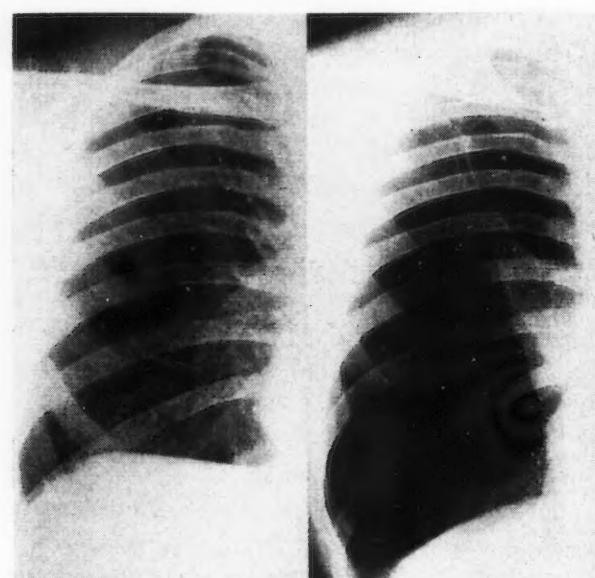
Preoperative (right) and postoperative (left) radiographs of case of multiple emphysematous bullæ of the right upper lobe treated by thoracotomy and excision of the bullæ. Thoracoscopy showed the bullæ and proved that what appeared to be adhesions on the radiograph of the pneumothorax were, in fact, the walls of a large bulla which had ruptured.
